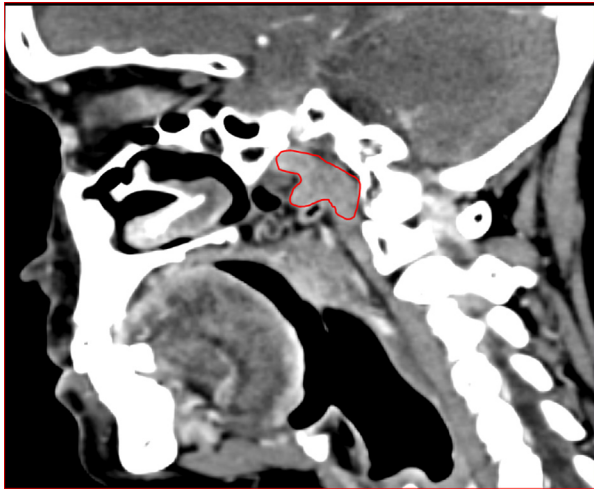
Sagittal contrast enhanced CT image showing the tubarial glands in the nasopharynx marked in red.
